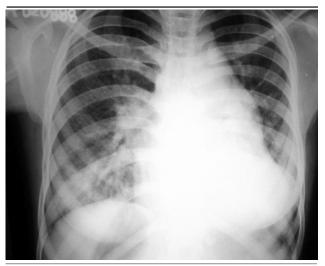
Chest X-rays showing Cardiomegaly and Dilated Pulmonary artery with plethoric lungs.
